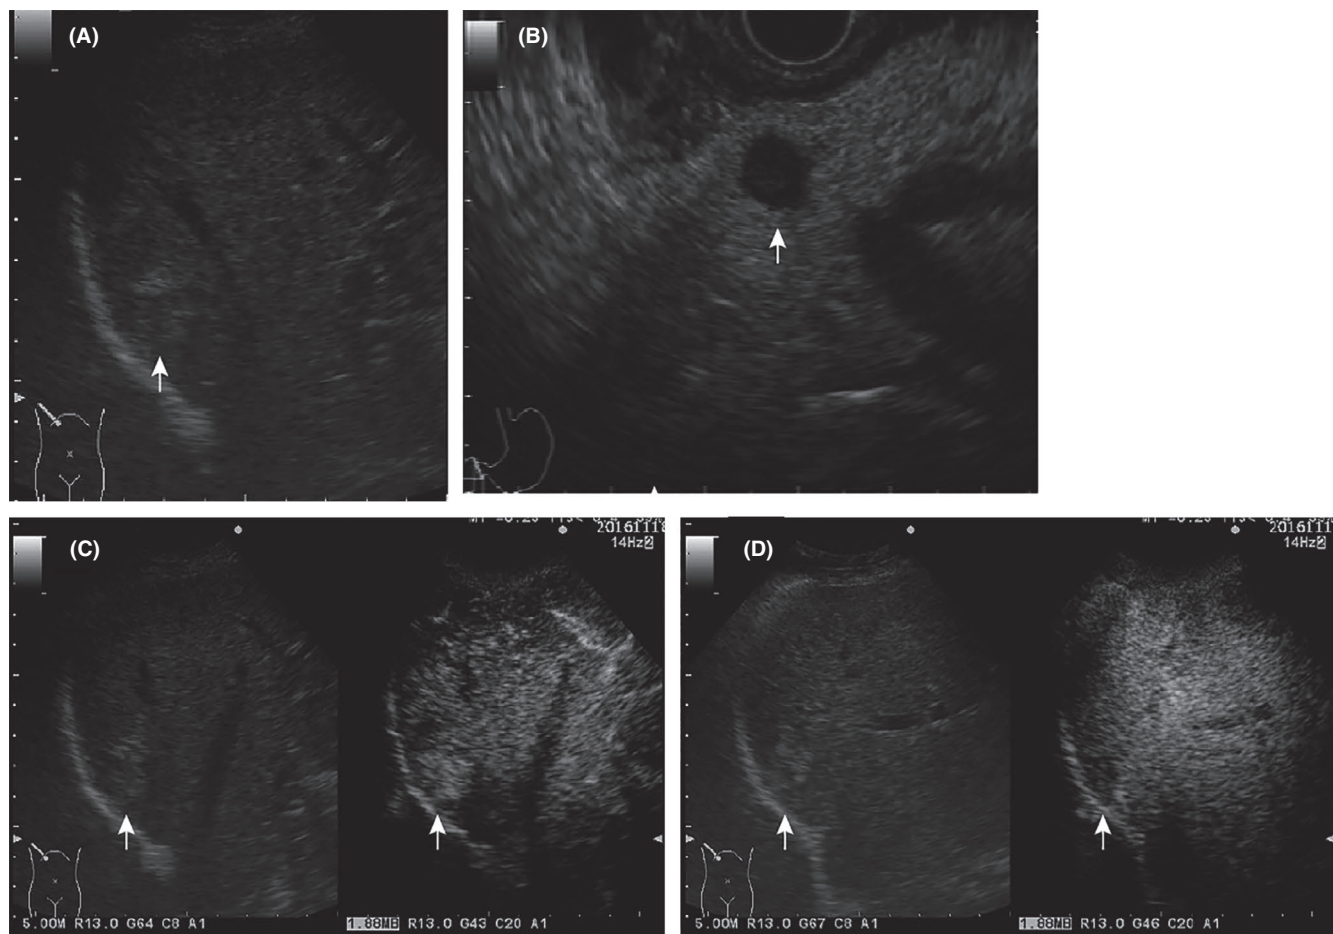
Ultrasound images. In the abdominal ultrasound examination, the hyperechoic tumor was located in segment 7 of the liver (A). Conversely, the pancreatic tumor was hypoechoic when viewed by endoscopic ultrasonography (B). Contrast-enhanced ultrasonography images are shown in C and D. Early enhancement of the liver tumor was observed in the vascular phase (C), and a perfusion defect was observed in the post-vascular (Kupffer) phase (D).
